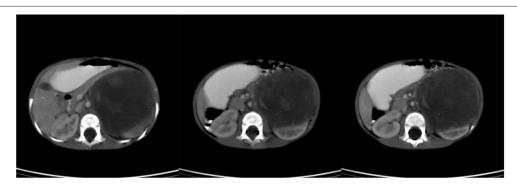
Preoperative CT scan of patient C.
